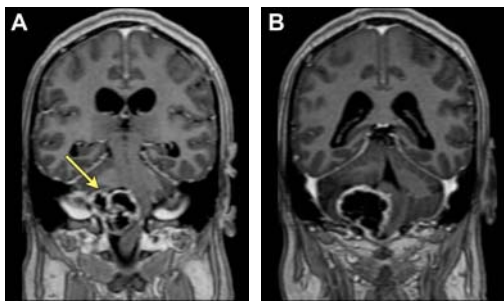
Preoperative coronal MRI with contrast showing large cystic mass compressing the brainstem and extending into the jugular foramen
